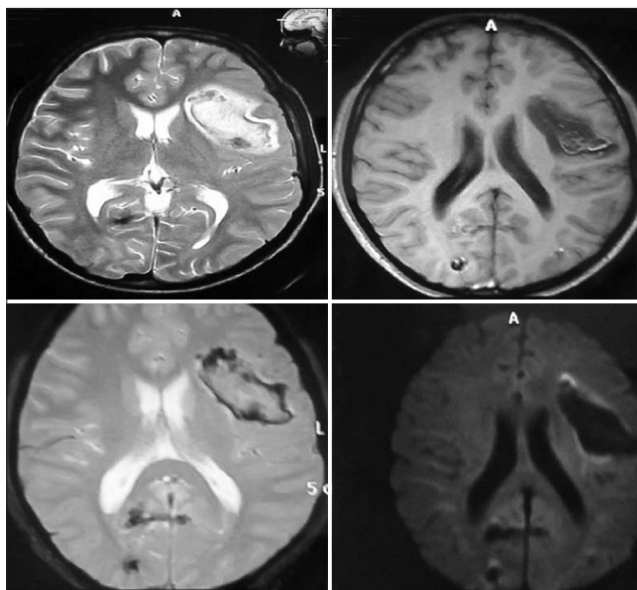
Magnetic resonance imaging brain T2, T1, GRE and DWI images showing acute hematoma in the left parietal lobe and microhemorrhage in the right occipital lobe
